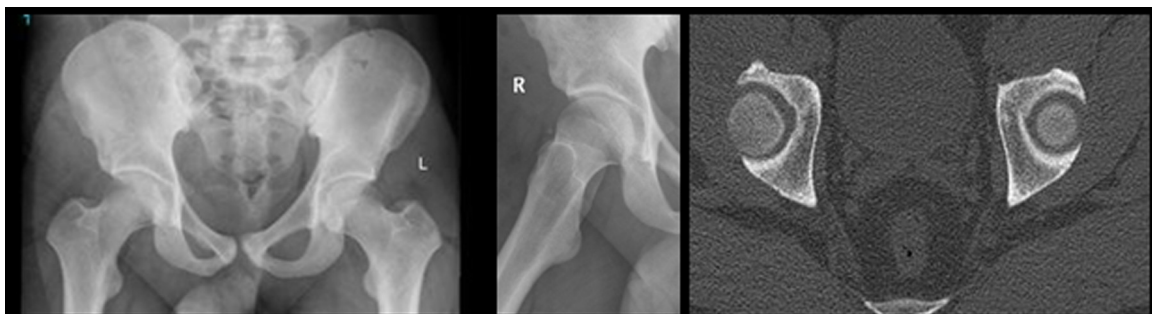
X-rays and CT films of right hip after surgery.
